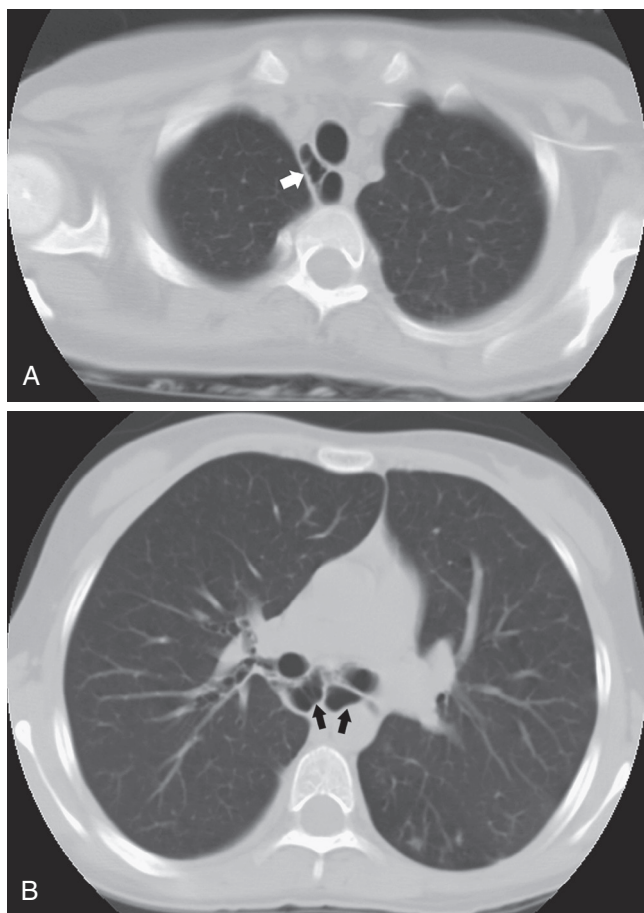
■ Tracheobronchomegaly (Mounier-Kuhn syndrome) in a 13-year-old girl with chronic cough and bronchiectasis. Computed tomography scan at the level of the trachea (A) and mainstem bronchi (B) shows air-filled sacculi (arrows) around the airway from chronic inflammation destroying the normal elastic properties of the tracheobronchial tree and its smooth muscles. (Courtesy Simon C. Kao, MD, Iowa City, IA.)
